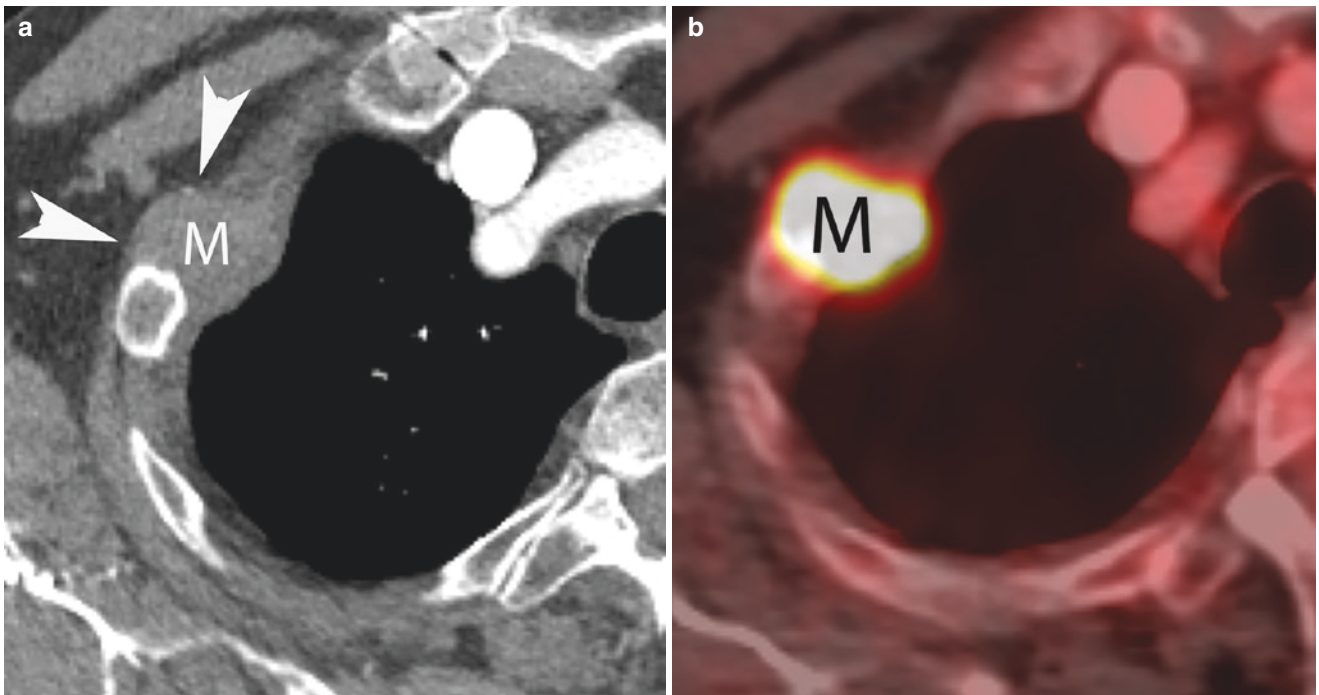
(a) Contrast-enhanced axial CT demonstrates a pleural mass (M) in the right upper thorax invading the chest wall (arrowheads), (b) Axial FDG PET/CT shows marked FDG uptake on PET/CT
